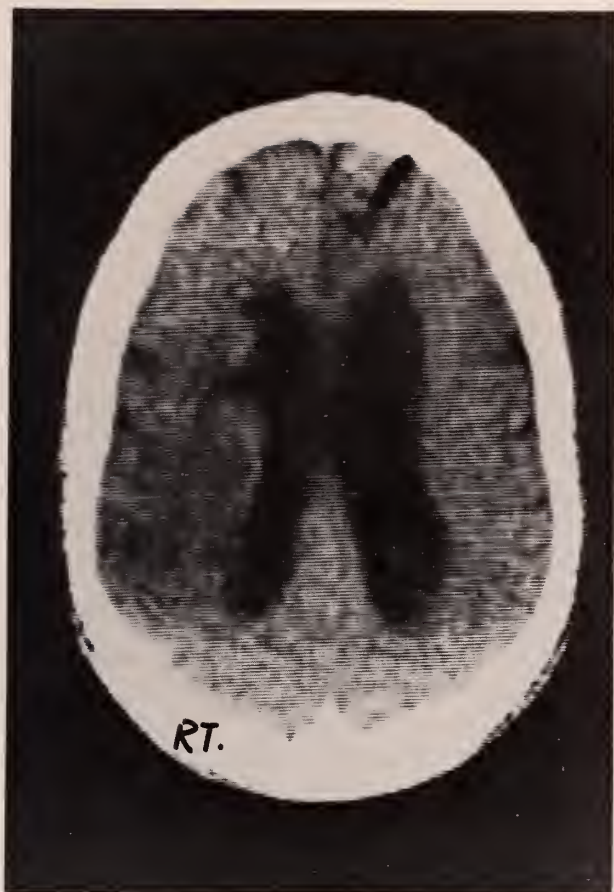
Case 2, late pre contrast CT scan, one month after stroke.
